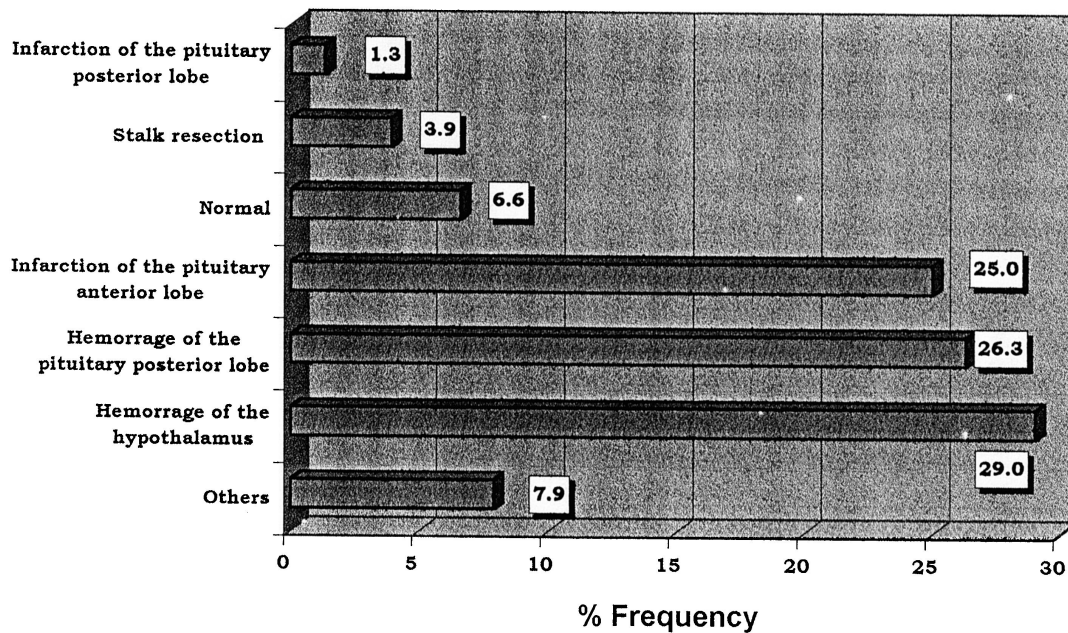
Anatomic lesions demonstrated by CT or MRI in patients with posttraumatic hypopituitarism.
